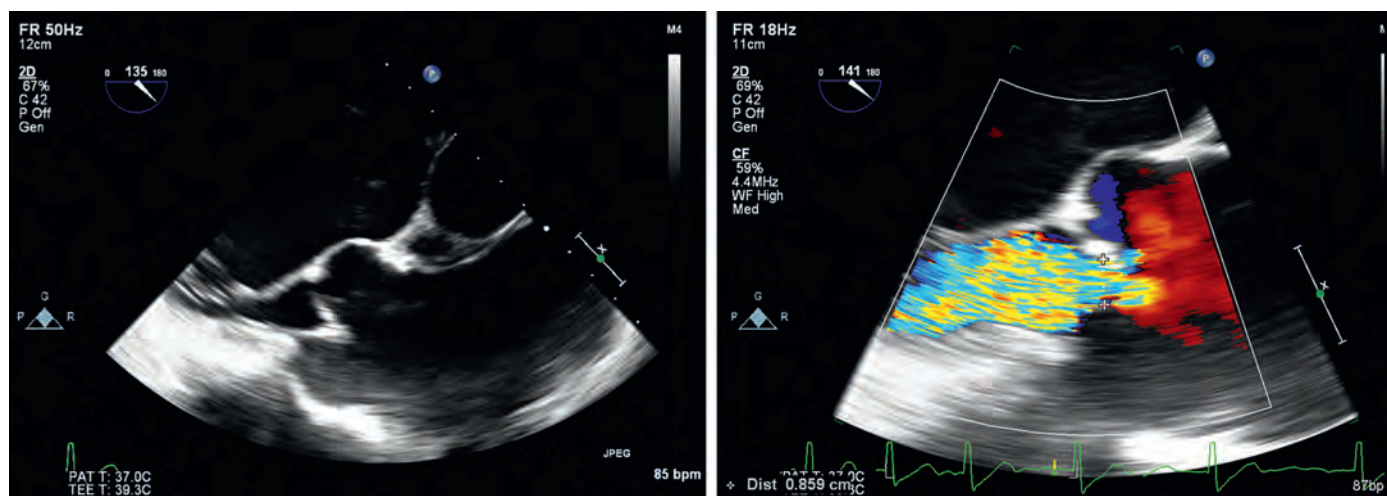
Functional aortic regurgitation (AR) secondary to an ascending aortic aneurysm. Midesophageal aortic valve (AV) long-axis view (left). The sinus of Valsalva is very enlarged with respect to the AV annulus. This enlargement results in tethering of the AV. The coaptation plane of the aortic leaflets is significantly distal to the plane of the aortic annulus (right). Addition of color-flow Doppler demonstrates severe AR.
